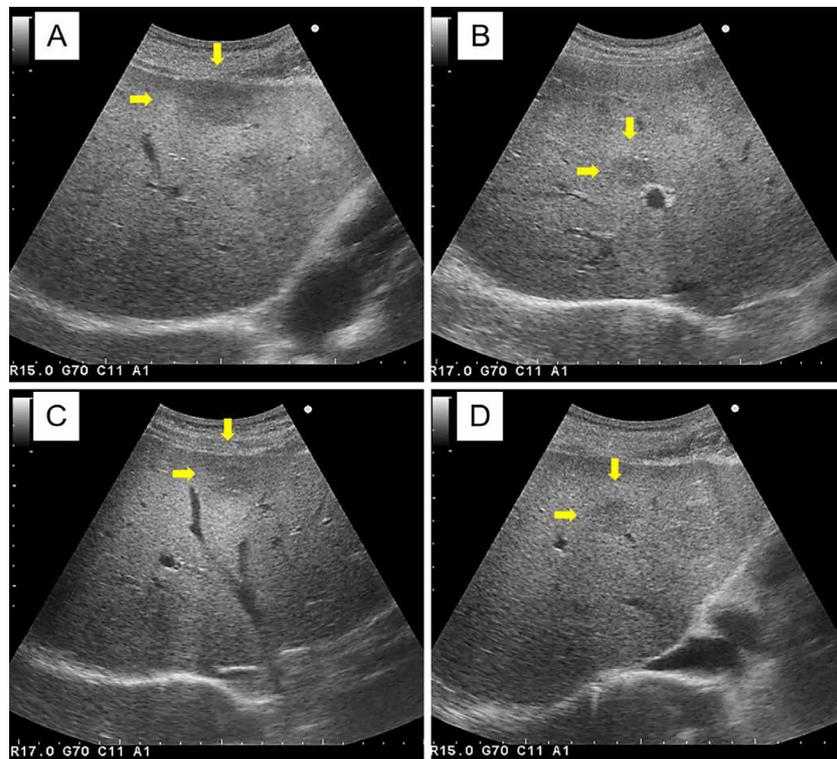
Abdominal ultrasound images. Multiple spherical nodules corresponding to the nodules on CT are detected. The nodules showed two types: those with well-defined borders (A, B; arrows) and those with ill-defined borders (C, D; arrows).
